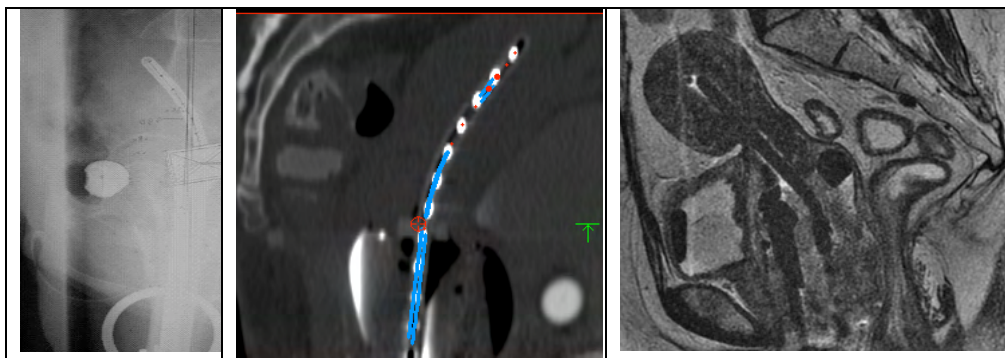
A comparison of plain film x-ray, CT and 3T MRI imaging for brachytherapy demonstrates the ability of plain films to show the applicator but not soft tissue, of CT to show the OAR but not the tumor, and of MRI to show the tumor and OAR.
